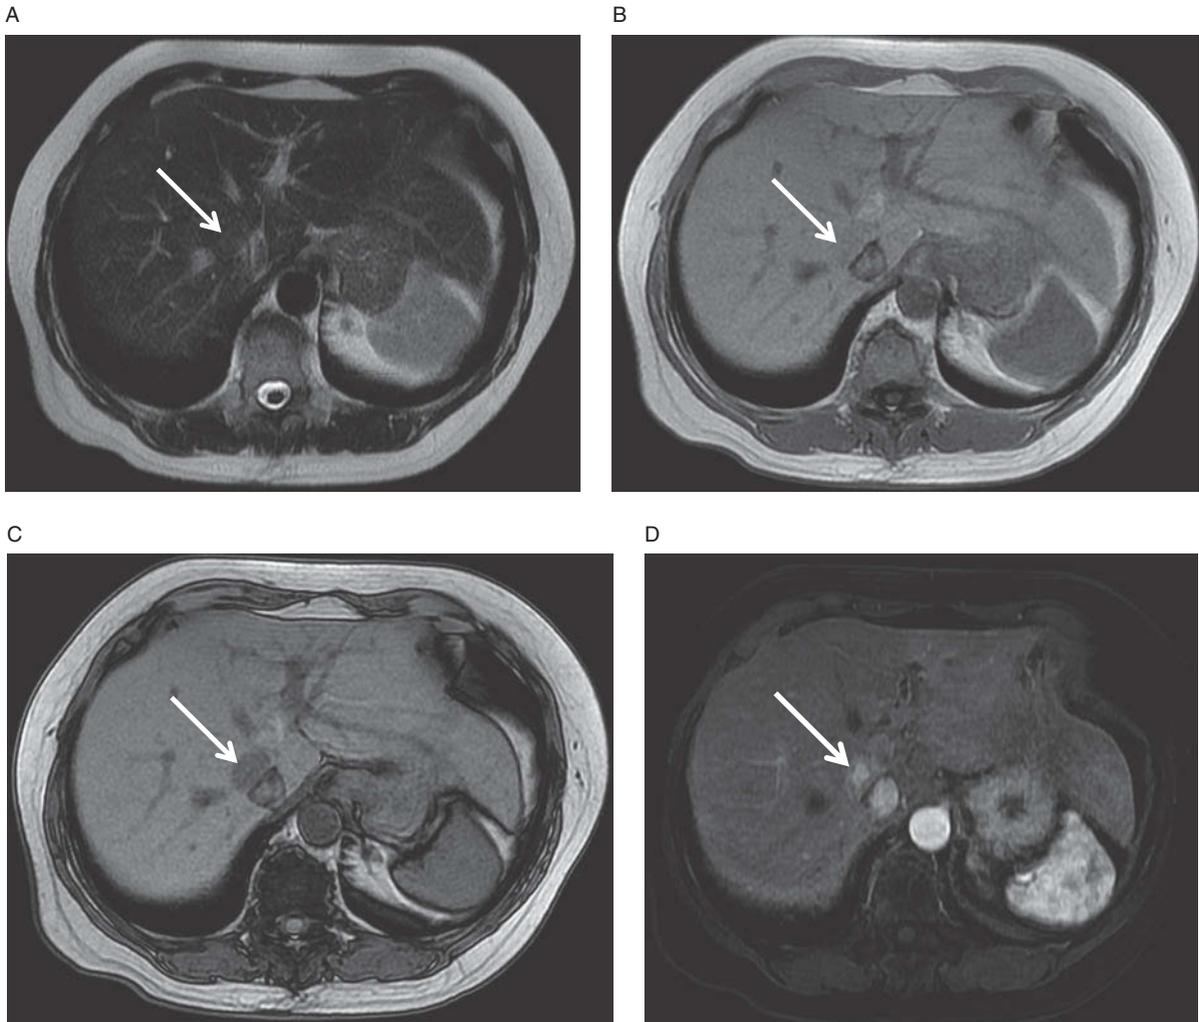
Hepatic adenoma. Lesion is not prospectively discernible on axial T2-weighted image (A). Most importantly, the lesion demonstrates marked signal loss on out-of-phase image (C) compared to in-phase image (B). Given that it is also hypervascular on arterial-phase image (D), it is most likely an adenoma. (See arrows).
